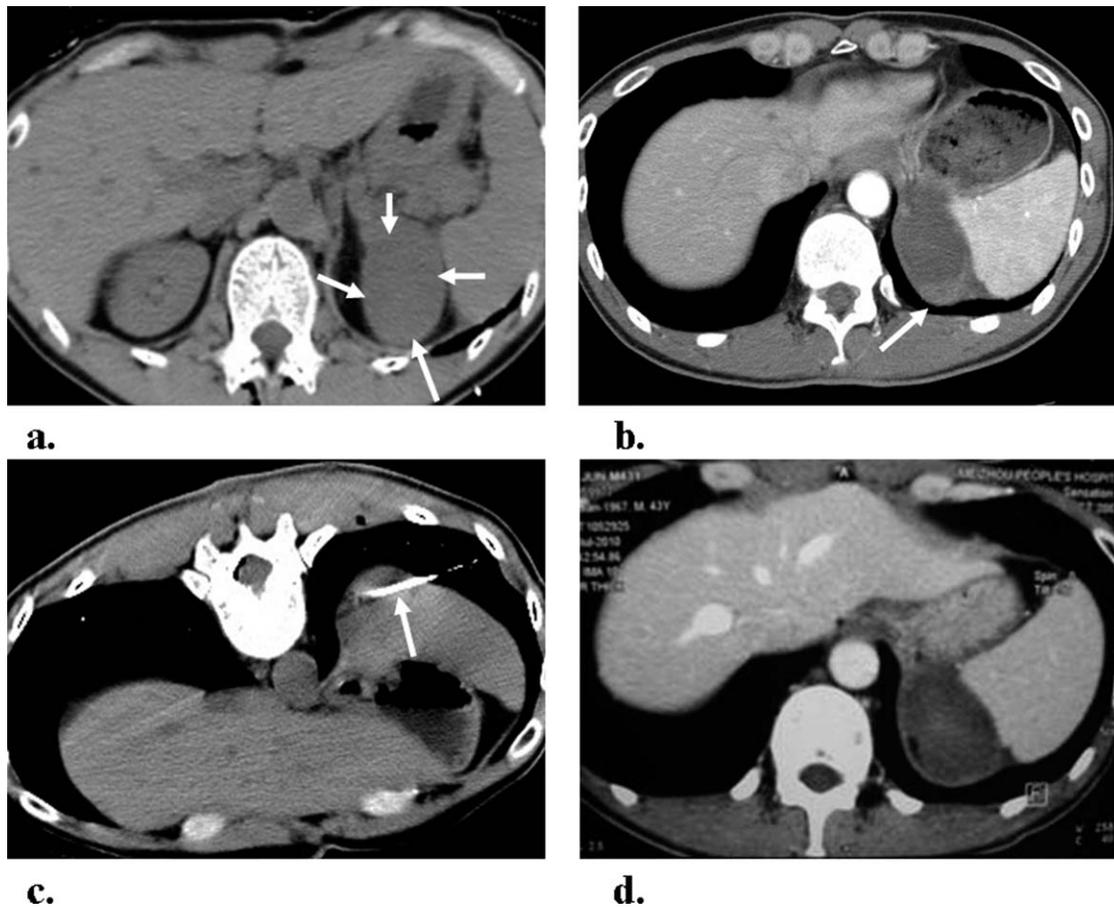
A 41-year-old male patient with left adrenal adenocortical carcinoma shows a local tumor relapse 1 month after radical surgery. After the patient received 2 stages of chemotherapy with taxotere + DDP, partial progression (PR) was evaluated. The patient received another 2 stages of taxotere + DDP chemotherapy to evaluate the status of progressive disease (PD). As shown in (a), leveled CT scan reveals that the tumor is oval and measures 6.1×3.8 cm (arrow). (b) Abdominal enhanced CT scanning one month after microwave ablation shows that the center of the tumor is completely necrotized, with residual enhancement areas (arrow). (c) A second microwave ablation is performed. (d) One month after the second ablation, follow-up reveals that there is no tumor enhancement.
